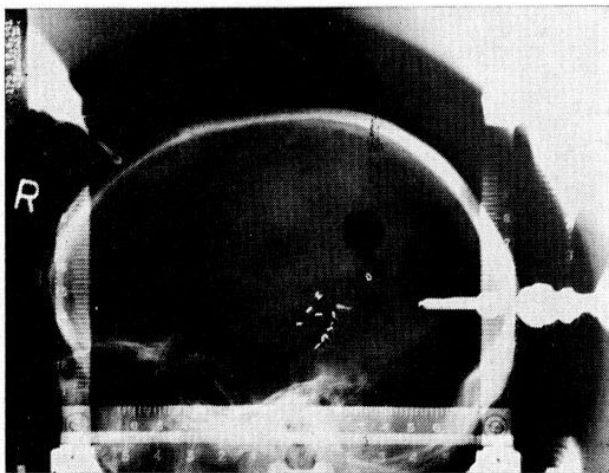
Case 3. Operative radiograph of gold seeds in position. Lateral view.
